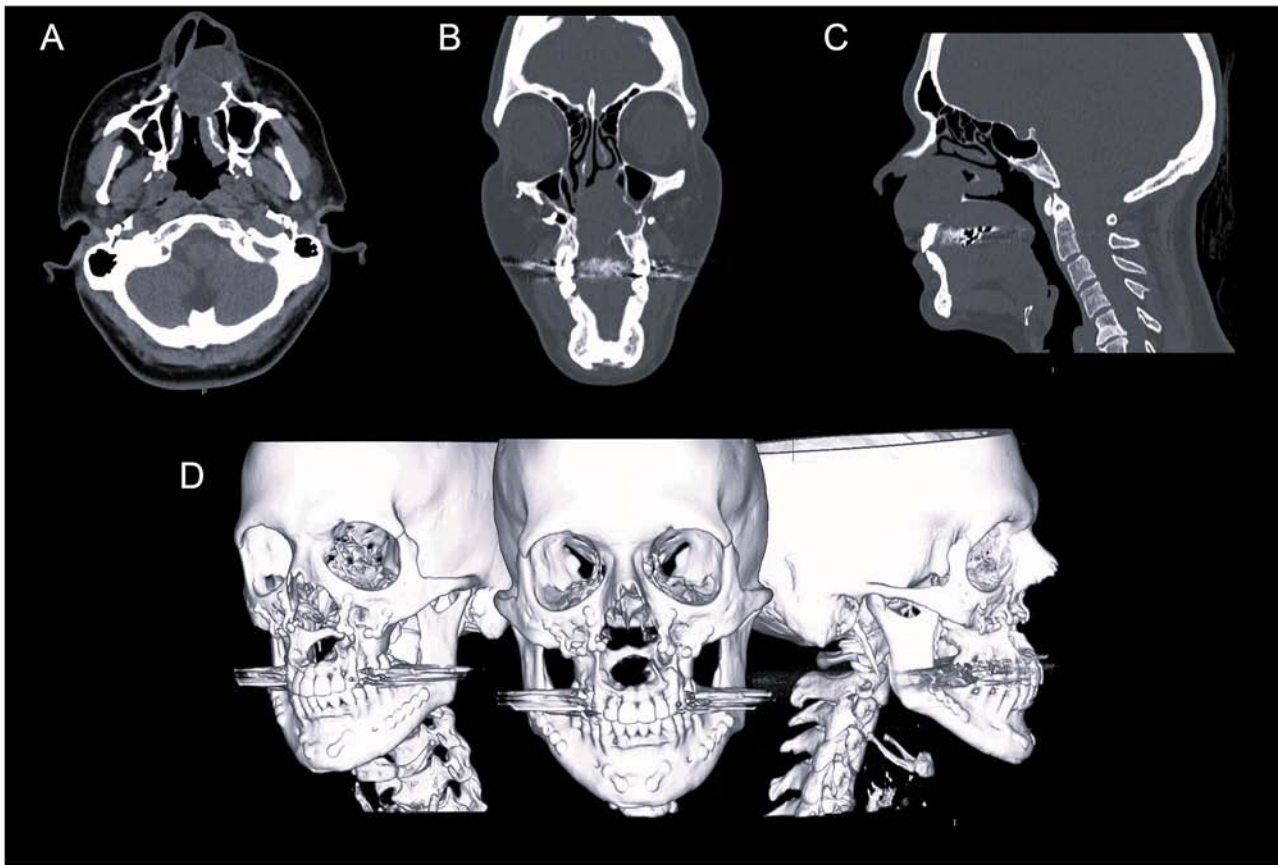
CT of the lesion in the (A) axial plane, (B) coronal plane, (C) sagittal plane and (D) 3D multiplanar volumetric reconstruction.
